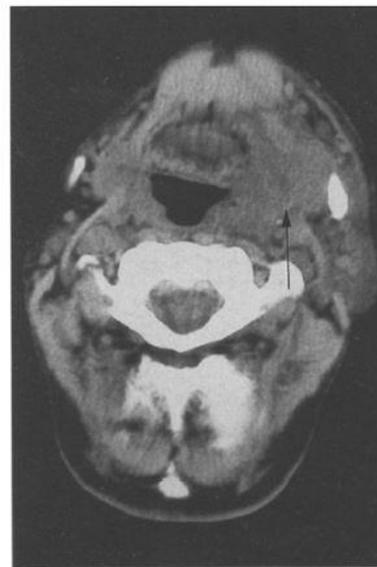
(Patient 9) Precontrast CT scan at level of angle of mandible, showing swelling in left submandibular region (arrow).
